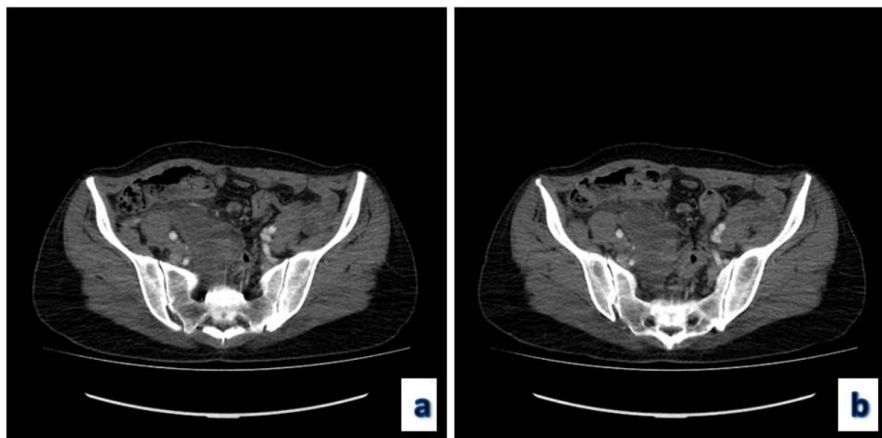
a, b. Abdominal computed tomography images of the patient before the laparoscopy
